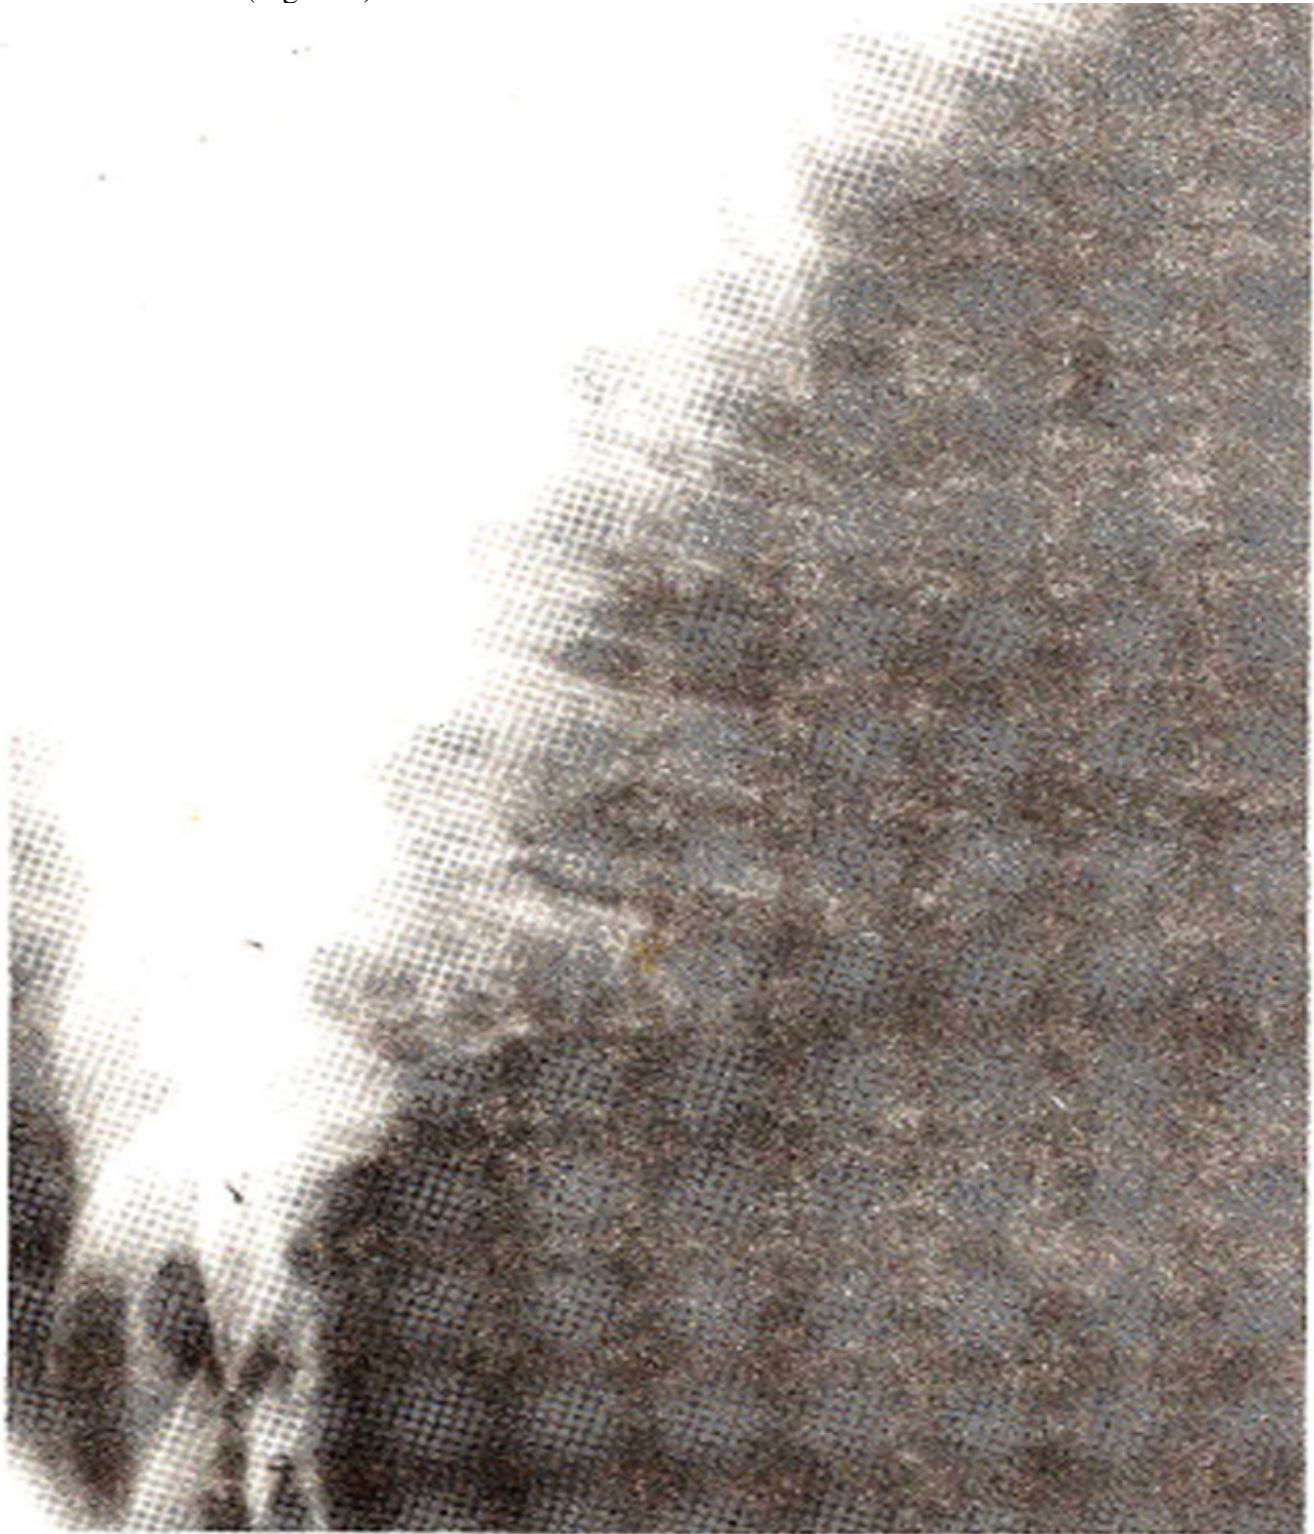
Lateral X-ray of dorsal spine showing collapse and ground glass appearance of 7th vertebra.
